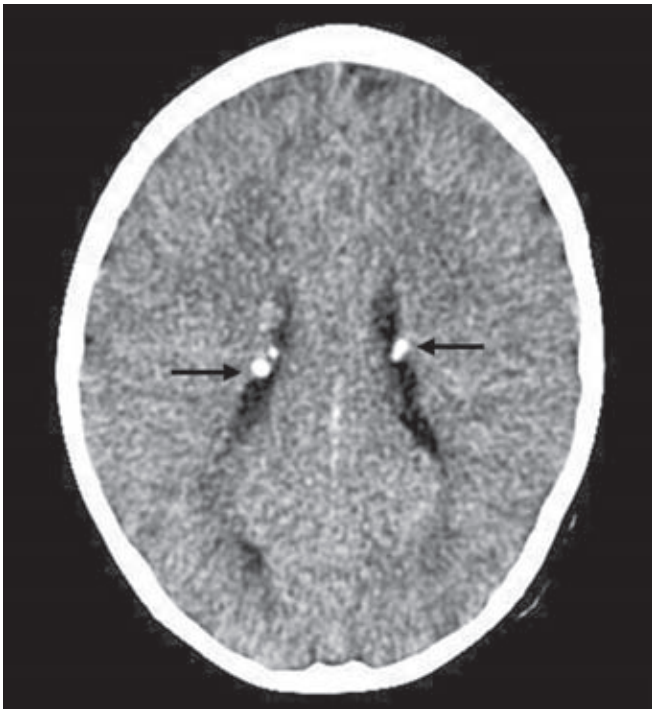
Tuberous sclerosis. Axial unenhanced CT scan of brain shows calcified subependymal nodules within both lateral ventricles (arrows)
